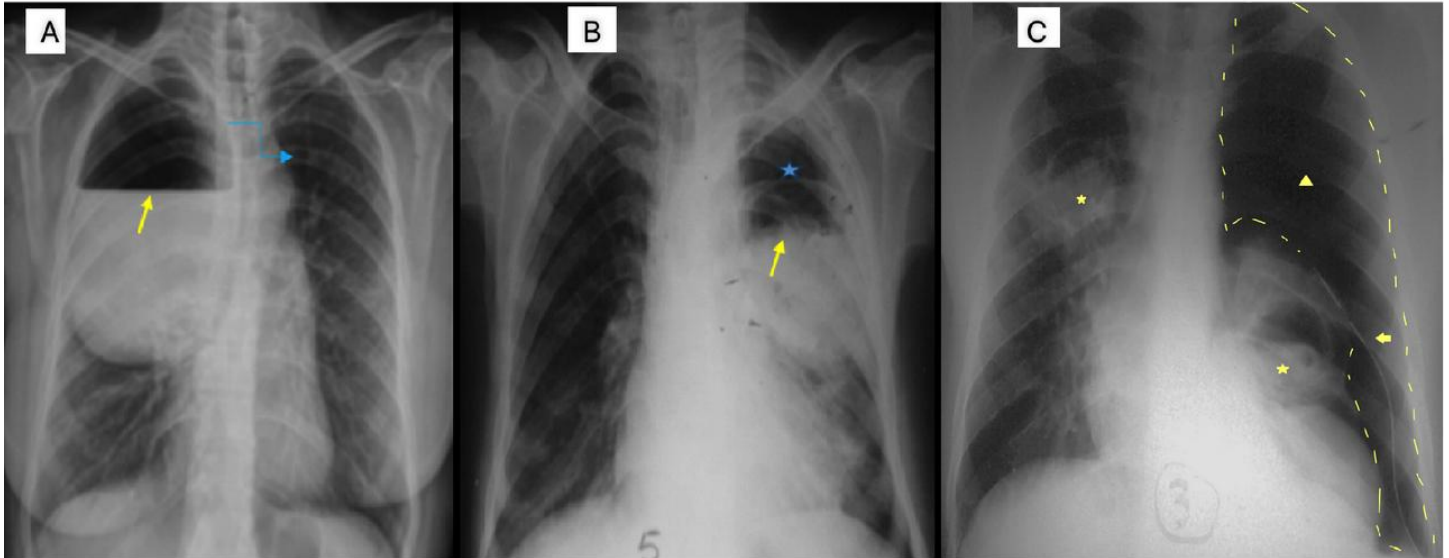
Chest radiographs of ruptured pulmonary hydatid cysts. (A) Large right upper lesion (~15 cm) with mixed density, air–fluid level (yellow arrow) and mediastinal shift (blue arrow), consistent with ruptured PHC. (B) Left mid-lung lesion (~8 cm) with mixed density and air–fluid level (yellow arrow), consistent with ruptured PHC. (C) Left hydropneumothorax with collapsed lung (yellow dashed line), mediastinal apposition (yellow triangle), pleural drain (yellow arrow), and intrapulmonary lesion (yellow star), with additional right basal 3 cm air–fluid lesion, consistent with bilateral ruptured PHCs. PHC, *Pulmonary Hydatid Cyst*.
